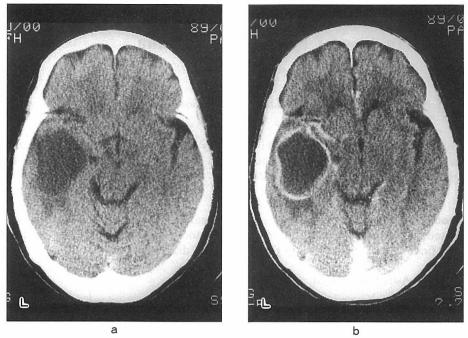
a: Plain CT shows a large low density area in the left temporal lobe. b: Contrast enhanced CT shows ringed enhancement with thin enhancing rim and smooth margin.
